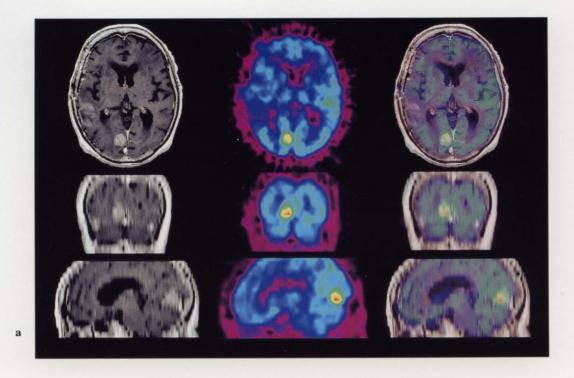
(a) FDG PET images (middle) are co-registered on MR images (left). Co-registered FDG PET images overlaid on MR image are shown (right). Metastatic brain tumor is visualized in the right occipital lobe on the both FDG PET and MR image. The tumor is well demarcated on the MR images. (b) A region of interest (ROI) is defined on the MR image (left) and transferred onto the FDG PET image (right).
